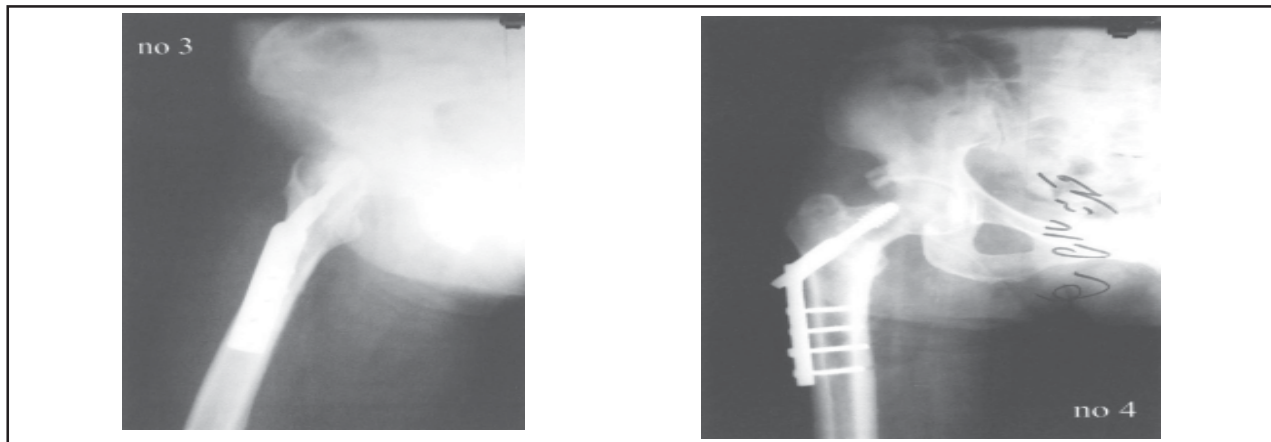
Radiography showing callus formation (4 weeks after surgery)
